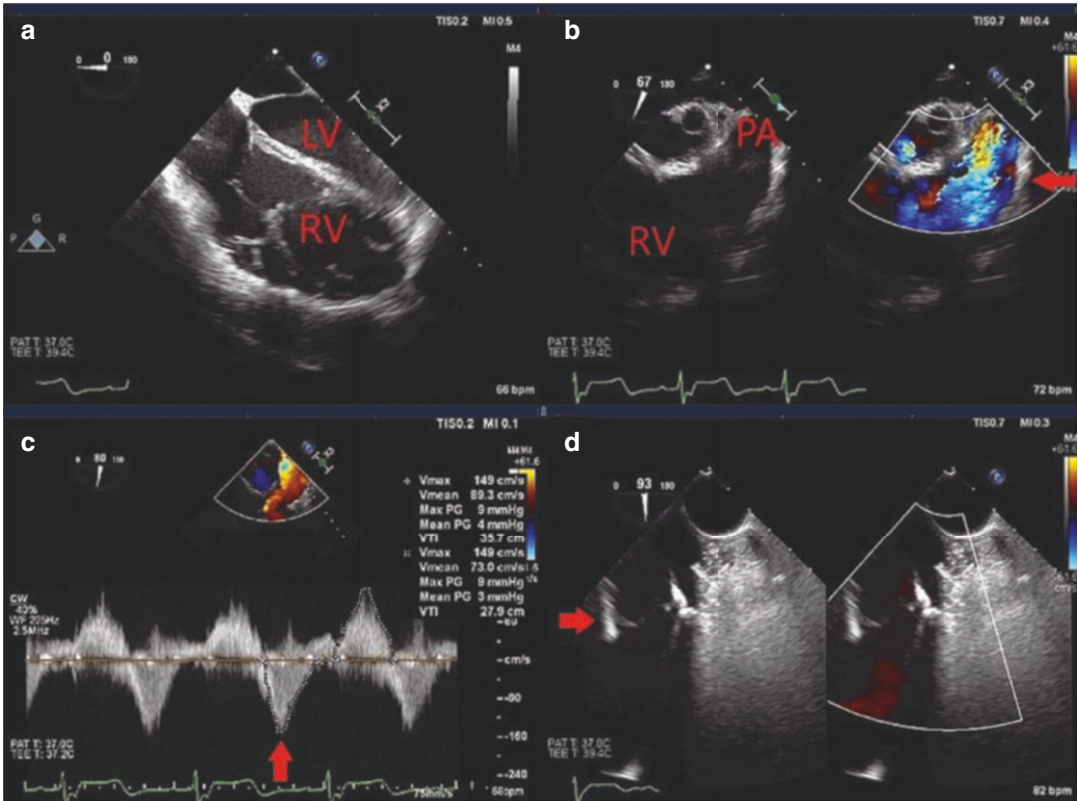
30 year-old female with repaired tetralogy of Fallot and chronic severe pulmonary regurgitation, referred for surgical pulmonary valve replacement. (a) Midesophageal 4-chamber view demonstrating a severely dilated right ventricle with prominent trabeculations, and small, underfilled left ventricle, (b) midesophageal short-axis view showing no residual pulmonary valve tissue (left panel), and color Doppler showing severe pulmonary valve regurgitation (right panel), (c) spectral Doppler tracing from the midesophageal 4-chamber view showing no
